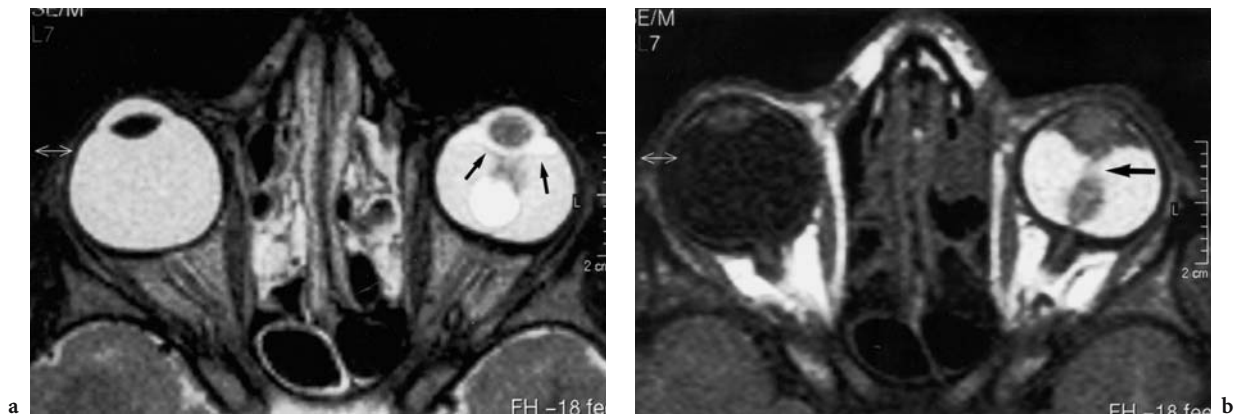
An 11-year-old boy with leukokoria and poor vision in the left eye. Diagnosis: persistent hyperplastic primary vitreous. MRI: a Axial T2-weighted image, demonstrating a small left eye with distorted lens. The very high signal material in the center might represent the compressed vitreous enveloped by subretinal hematoma. The slight hypodense lines correspond to the displaced retina (*arrows*). b Corresponding T1-weighted image with hyperintense signal of the intraocular hemorrhage accompanying retinal detachment. Note the isointense structure, connecting the optic disc with the lens (*arrow*). (With the permission of KUEKER and RAMAEKERS 1999)
